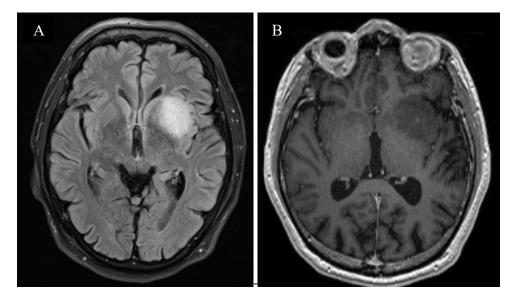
A-B (A) Axial FLAIR in a Diffuse Astrocytoma WHO grade II (B) Axial T1w with i.v. gadolinium contrastT2/FLAIR demonstrate a well described non-contrast enhancing tumor in the left insula.
